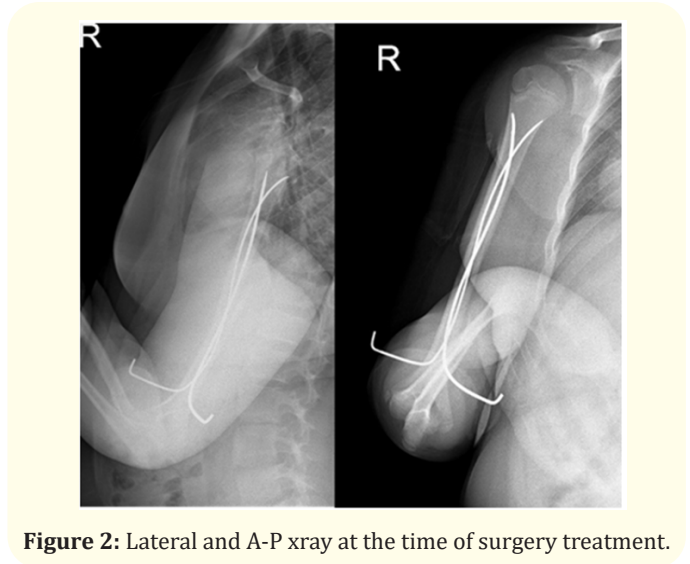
Lateral and A-P xray at the time of surgery treatment.
